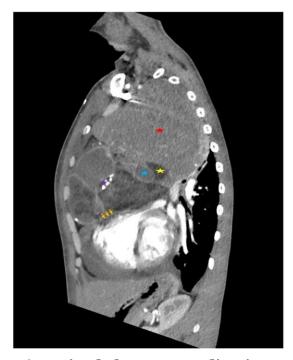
The contrast-enhanced chest CT. a) Sagittal chest CT mediastinum window minimal pericardial effusion (yellow arrows). b) Coronal chest CT mediastinum window showing masses pressing on the vena cava and bilateral pulmonary a/v (green arrows)
